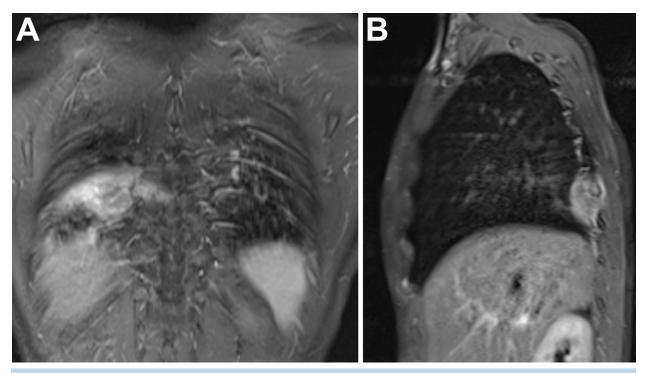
(A) Post-contrast T1 weighted coronal MRI of chest. The large metastatic lesion of the right posteromedial eighth rib is seen. (B) Post-contrast T1 weighted MRI showing a sagittal view of the rib lesion.
